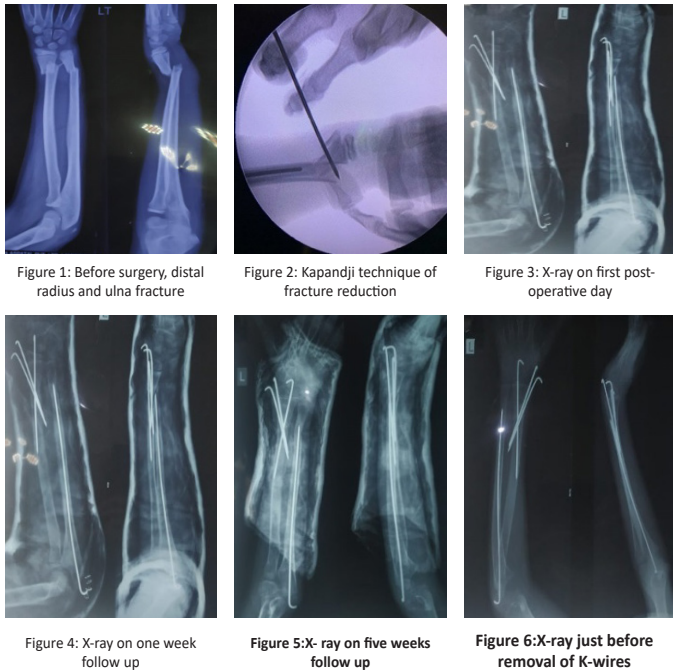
Sequential radiograph of distal radius fracture associated with ulna fracture.
